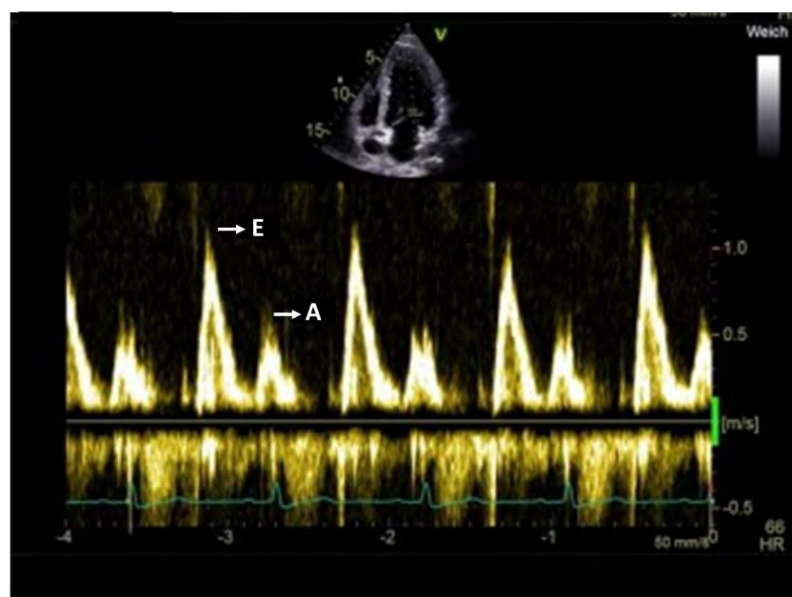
Doppler velocity curves of mitral valve inflow.
